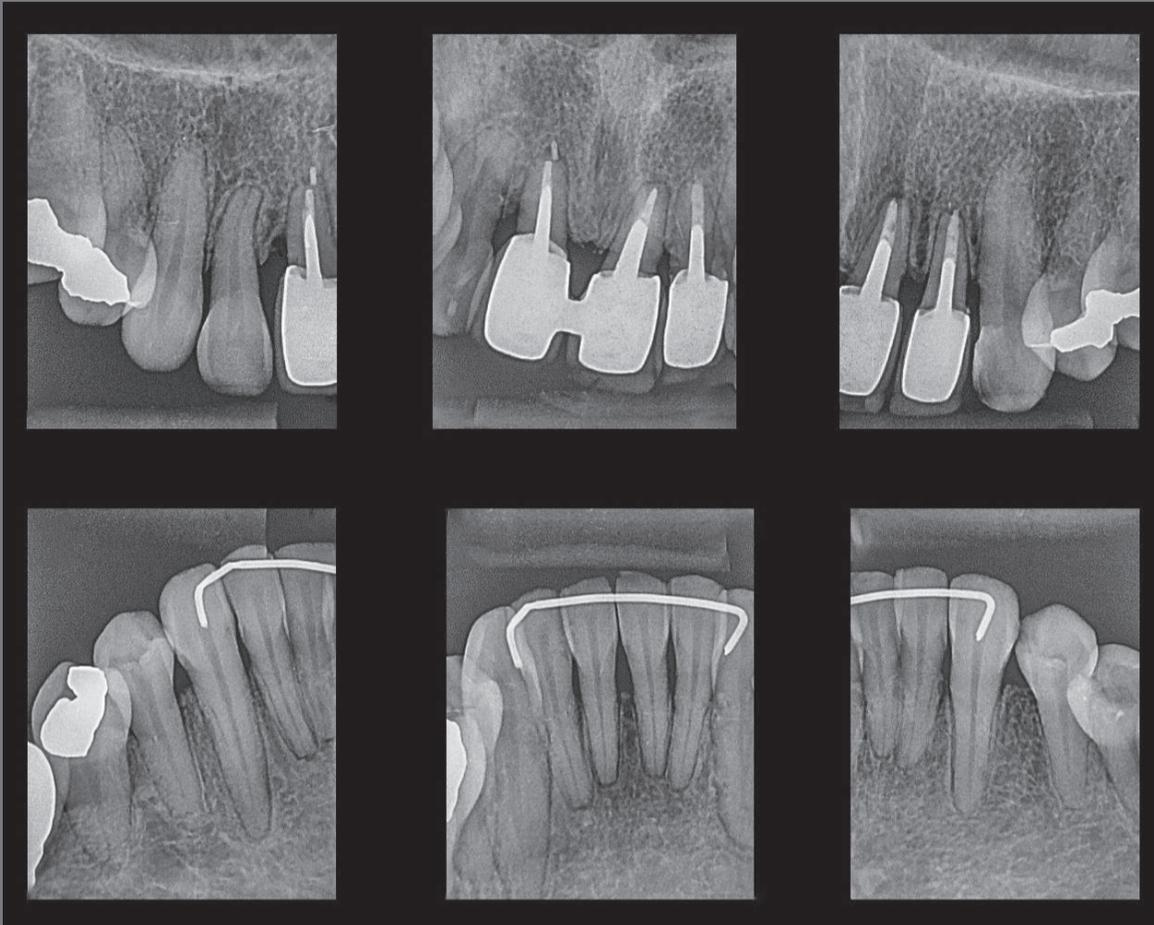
Periapical radiographs 8 years after the end of treatment.
